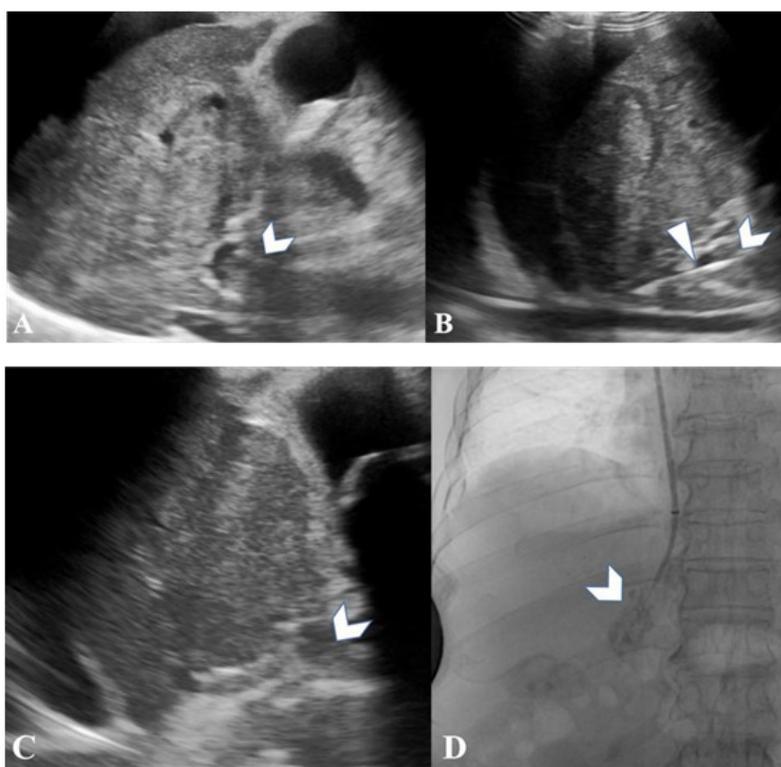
Ultrasound (US)-guided portal vein access in patient with tumor thrombus in portal vein. (A) Sonogram showed that the portal vein was filled with isoechoic mass (white arrowhead). (B) Advancement of needle (white triangle) under US guidance into right portal vein (white arrowhead). (C) Agitated saline is injected to confirm the portal entry, shown as a cloud of echoes by sonogram (white arrowhead). (D) Contrast agent is injected to re-confirm and outline the portal entry (white arrowhead).
